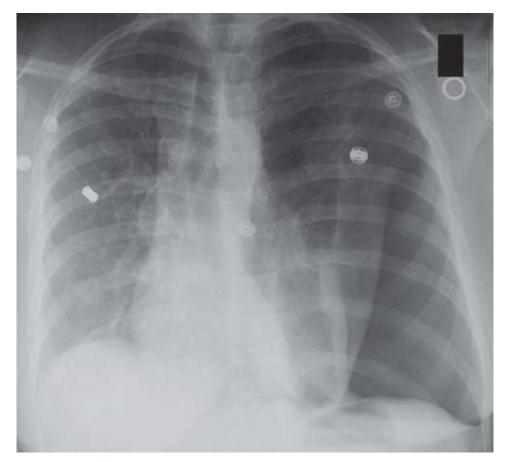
Plain chest x-ray of a patient with tension pneumothorax demonstrates tracheal deviation and shift of the mediastinum away from the side of the tension. Depression of the ipsilateral hemidiaphragm is also noted. (Photo courtesy of open access clinicalcases.org CC-BY-SA-2.5.)
